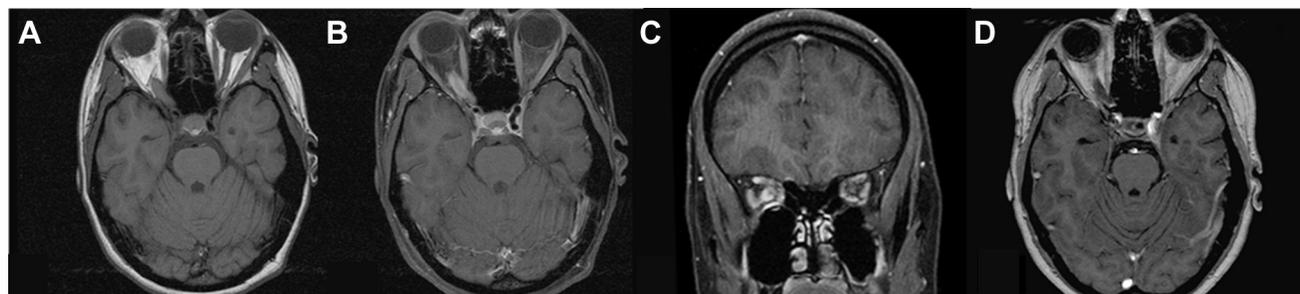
Neurosarcoidosis. A 26-year-old woman who presented with progressive decrease of visual activity in the left eye. (A) Axial T1-weighted magnetic resonance (MR) image showing thickening of the right optic nerve compared with the left. (B) The enlarged optic nerve enhances
